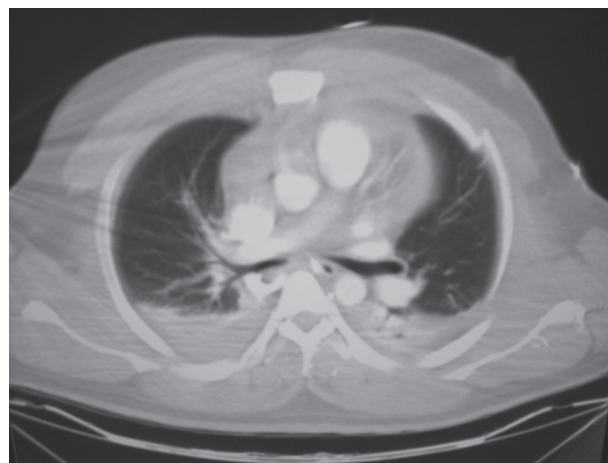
Multiple rib fractures seen on chest computed tomography (CT) scan. (Also note presence of bilateral hemothoraces.)
